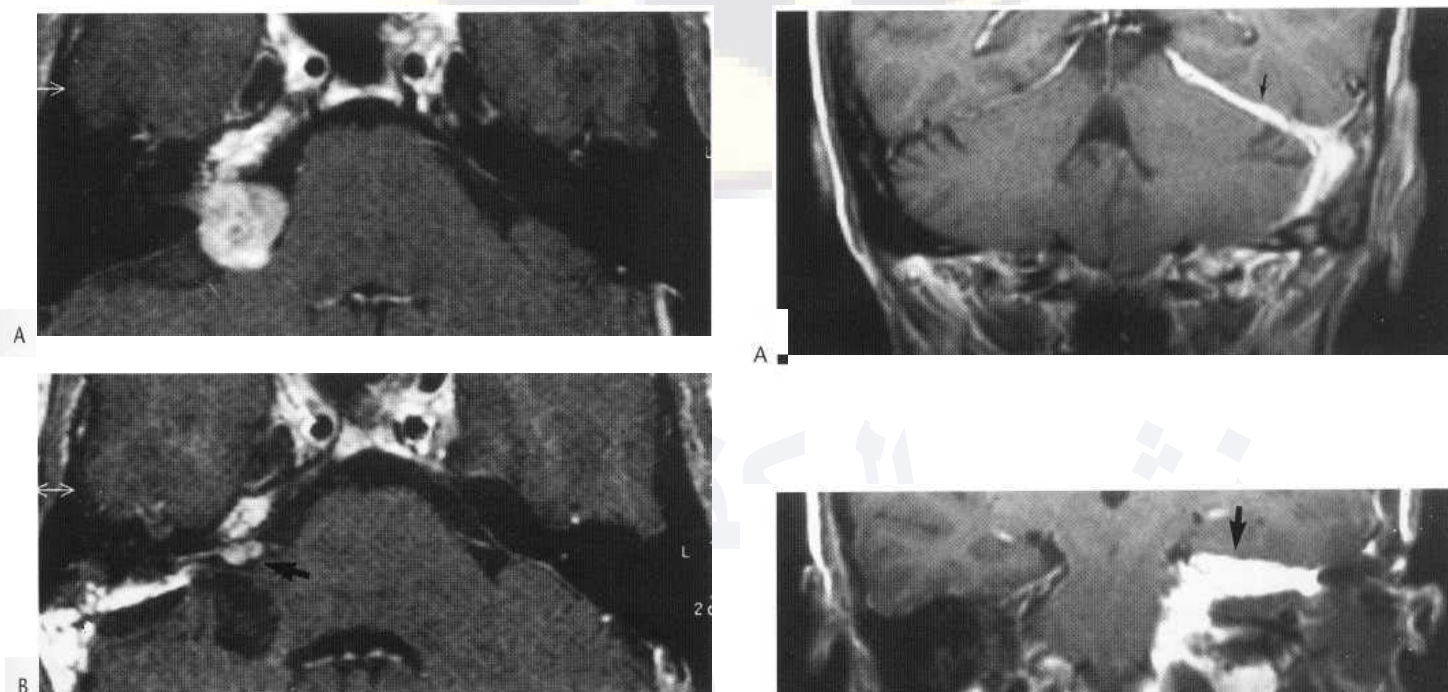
(A) Axial Gd-MRI showing a large acoustic neuroma in the cerebellopontine angle and medial part of the IAM. (B) The bulk of the tumour has been removed but a small segment adherent to the facial nerve has been left deliberately (arrow) to preserve facial nerve function and will be monitored for growth on subsequent scans. Note the 'hole' in the posterior cranial fossa.
